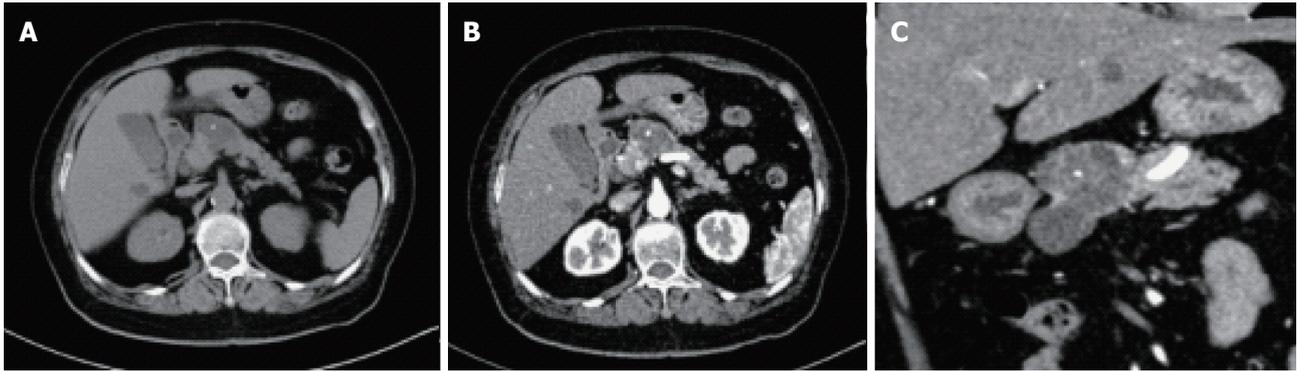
Central calcifications were found by computed tomography with and without enhancement (A and B), and also shown after three dimensional reconstruction (C).
